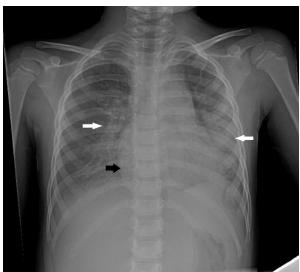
Chest radiograph showing cardiomegaly (black arrow) and pulmonary edema (white arrows).
